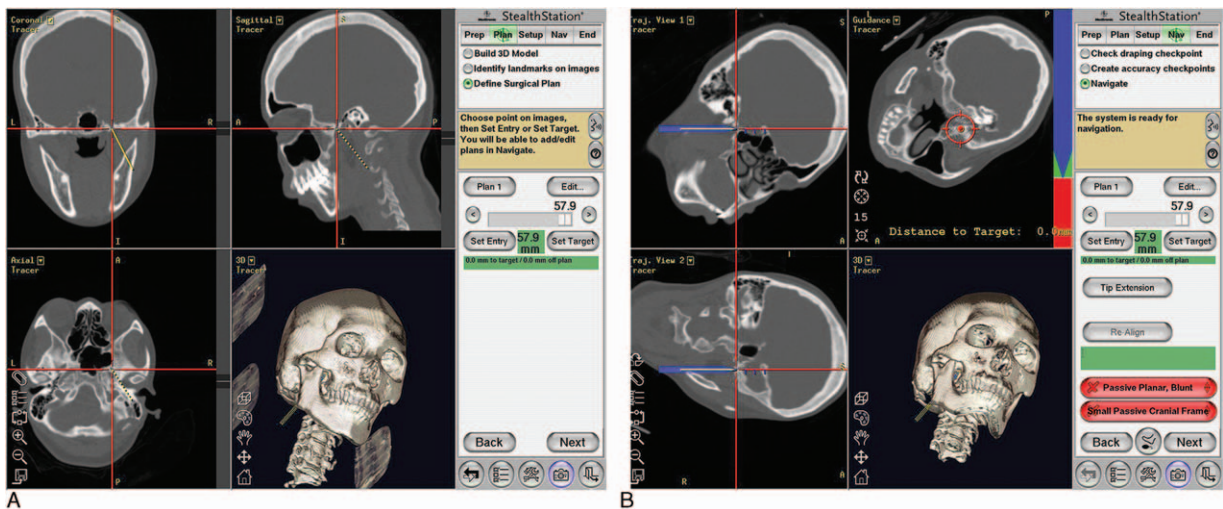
Computed tomography image and neuronavigation. (A) Defined surgical plan; (B) neuronavigational puncture trajectory.
